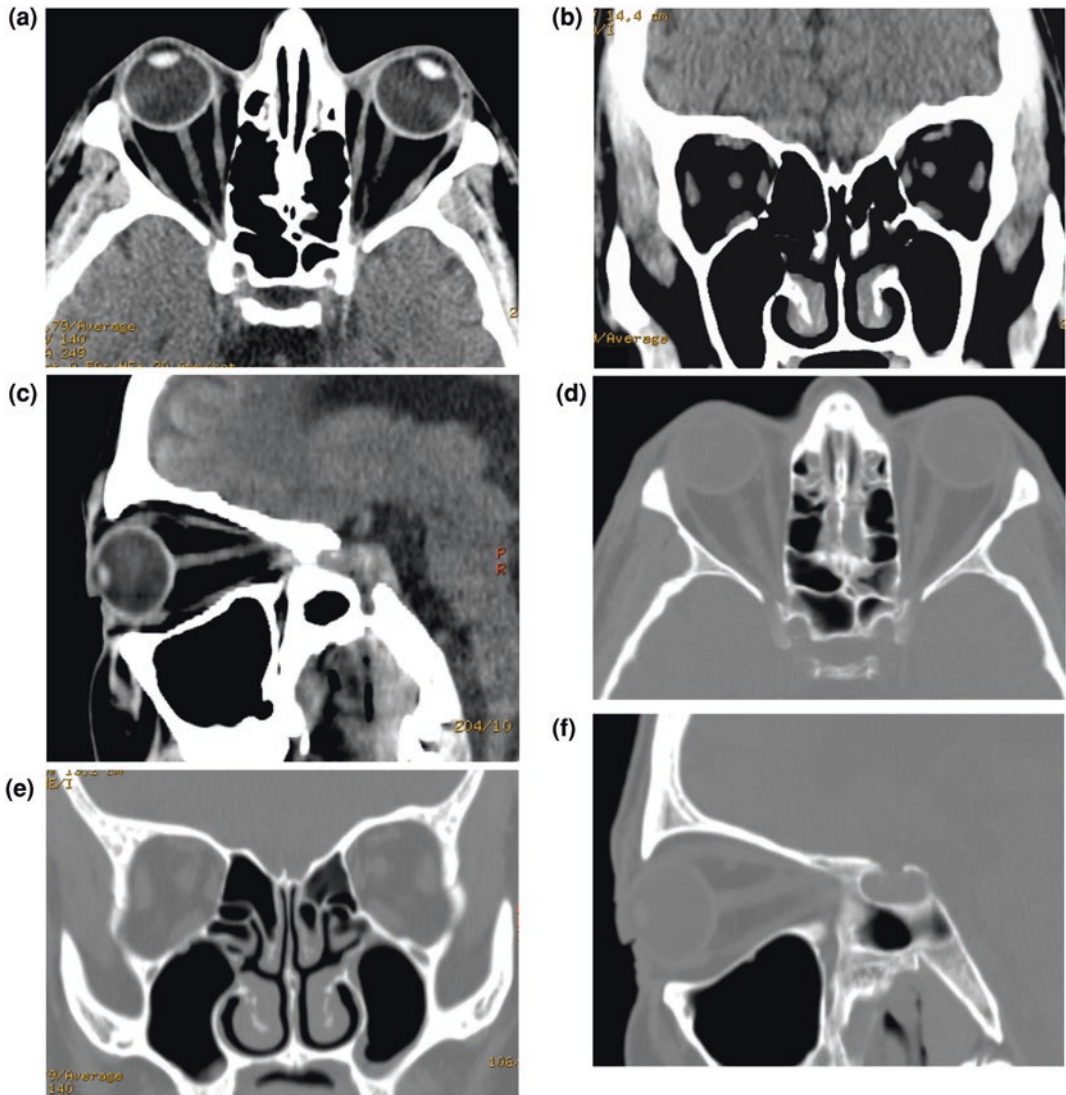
Normal orbit on CT imaging. a–f Axial, coronal and sagittal reformatted CT images in soft tissue a–c and bone windows d–f showing normal appearance of the extraocular muscles, optic nerve and retro-orbital fat
